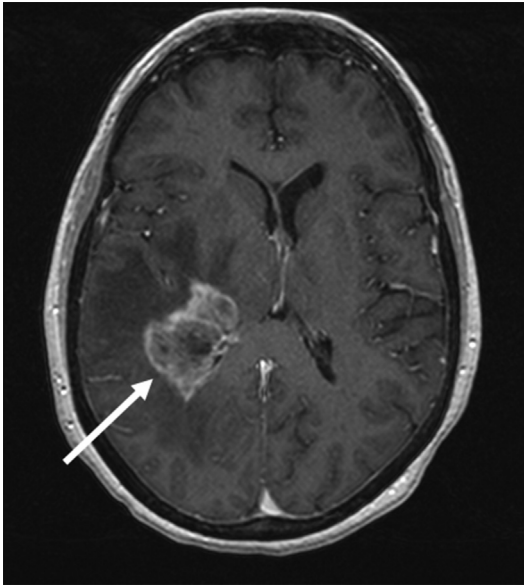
Example of high-grade glioma (glioblastoma) demonstrating avid contrast enhancement on T1-weighted MRI sequence. The arrow indicates the tumor in the posterior right temporal lobe.
